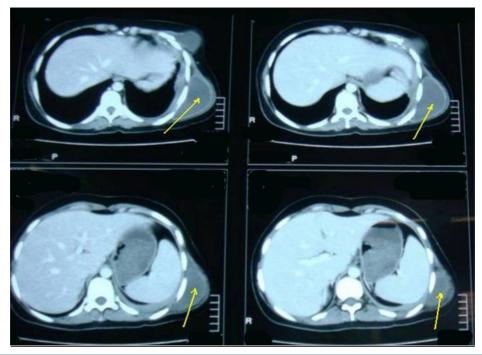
Computed tomography of the thorax. The arrow shows a cold abscess. It also shows features suggestive of destruction and pathological fracture of the left sixth rib with low density fluid collection in the left pleural cavity, left side of the chest wall and the region inferior to left breast suggestive of cold abscess.
